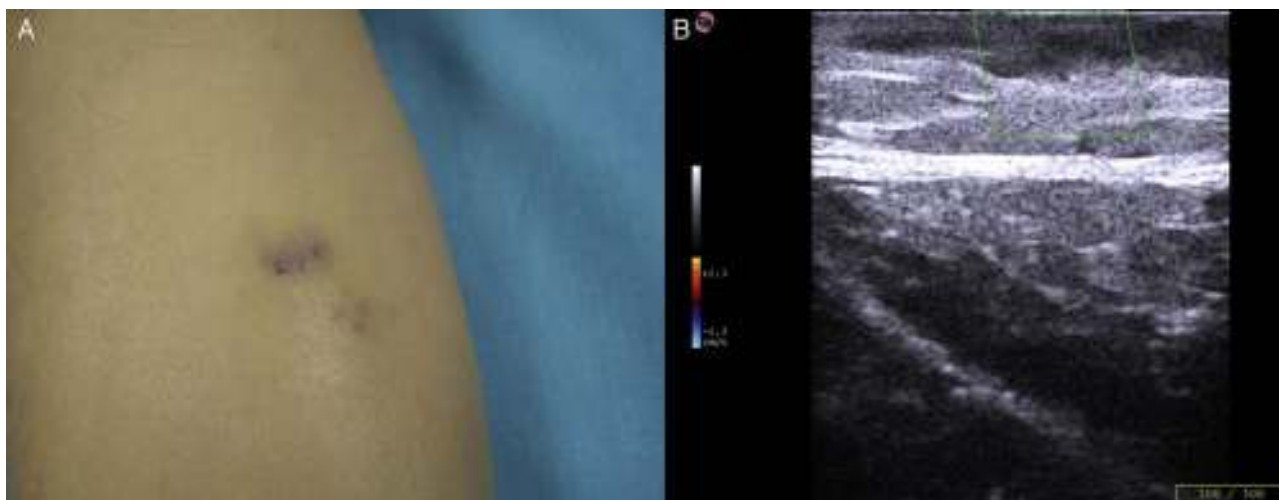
A, Reddish-violaceous plaque on the anterior surface of the left thigh. B, The ultrasound examination revealed a solid, hypoechoic, heterogeneous lesion with irregular, acicular edges in the papillary dermis. Color Doppler did not reveal intralesional vascularization.
